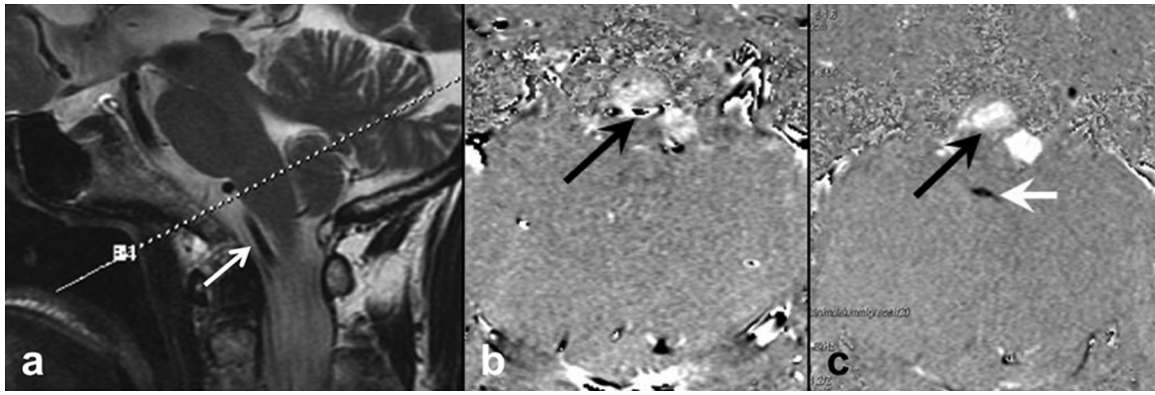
(a) The basilar trunk (white arrow) observed on a T2W image (b) generates artefacts in the prepontine cistern (PPC) represented by an aliasing of the signal (black arrow) with a conventional cine PC-MRI. The advantage of the developed sequence is clearly demonstrated (c) with the incorporation of saturation bands to negate the signal from flowing blood (black arrow). Furthermore, by reducing the  $V_{enc}$  to 20 mm/s, the foramen of Magendie appears with good contrast and can be segmented easily (white arrow).
